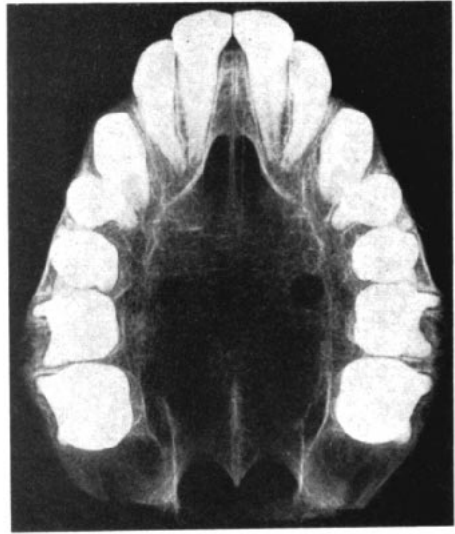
Occlusal radiograph showing restoration of normal palatal morphology.
